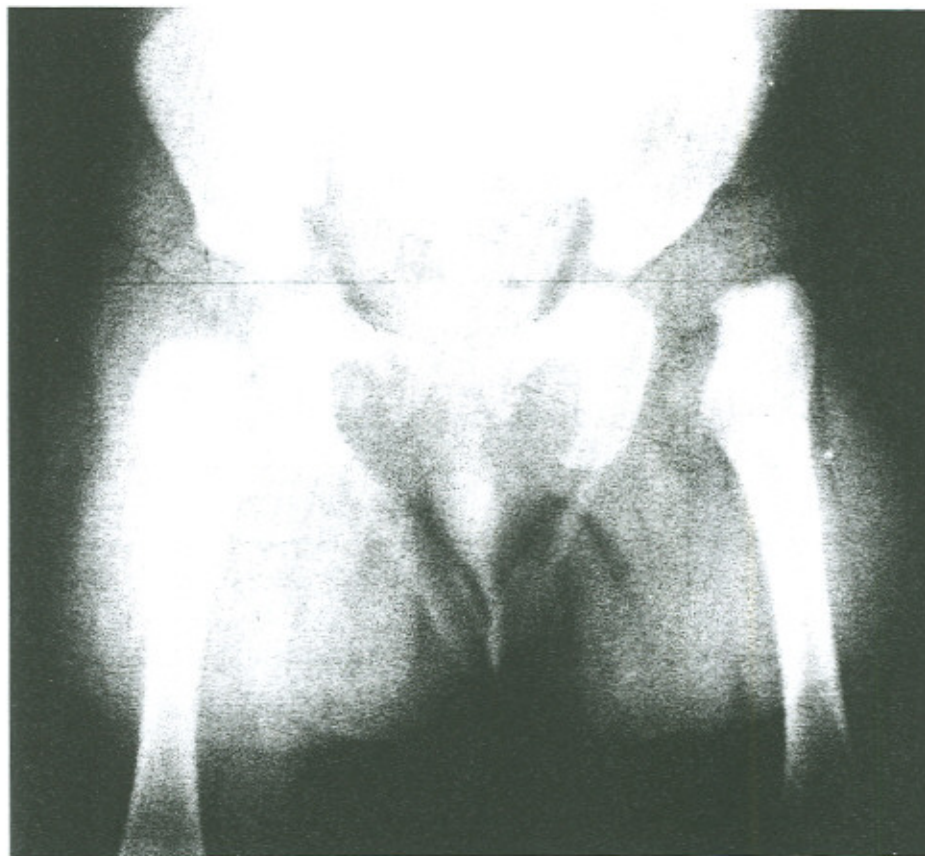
An anteroposterior radiograph of the pelvis. The left proximal femoral metaphysis is displayed superolaterally and the acetabulum is shallow and hypoplastic.
